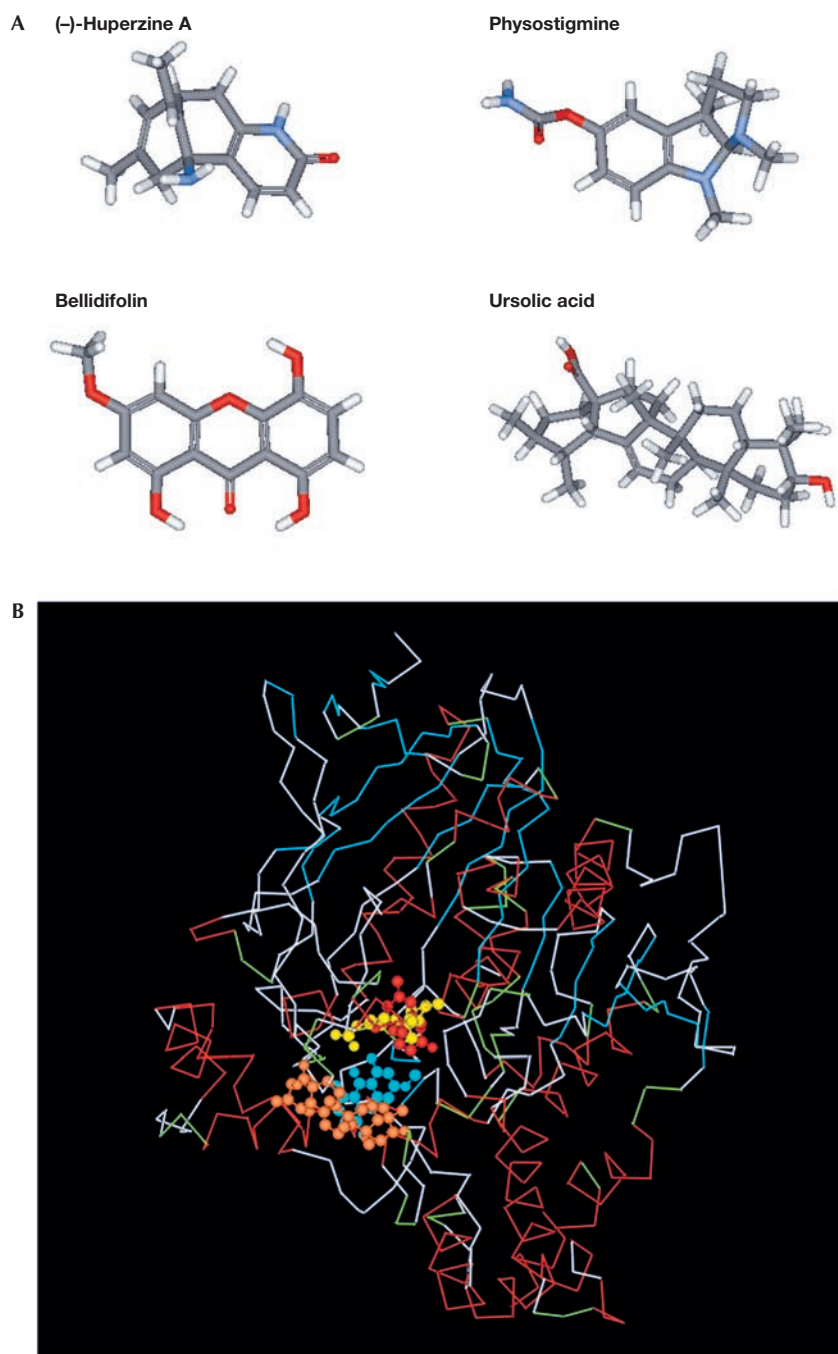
Molecular structures of natural inhibitors of acetylcholinesterase. (A) (-)-Huperzine A ($EC_{50} = 0.1$ nM), physostigmine ($EC_{50} = 0.6$ nM), bellidifolin ($EC_{50} = 0.15$ nM) and ursolic acid ($EC_{50} = 7.5$ nM). (B) Binding sites of these inhibitors on the acetylcholinesterase. (-)-Huperzine A is shown in red, physostigmine in yellow, bellidifolin in cyan and ursolic acid in orange. The X-ray structure of acetylcholinesterase and (-)-huperzine A was obtained from the Protein Data Bank (entry 1VOT). The binding of the other three inhibitors was calculated by using the FlexX module of SYBYL 7.0.
